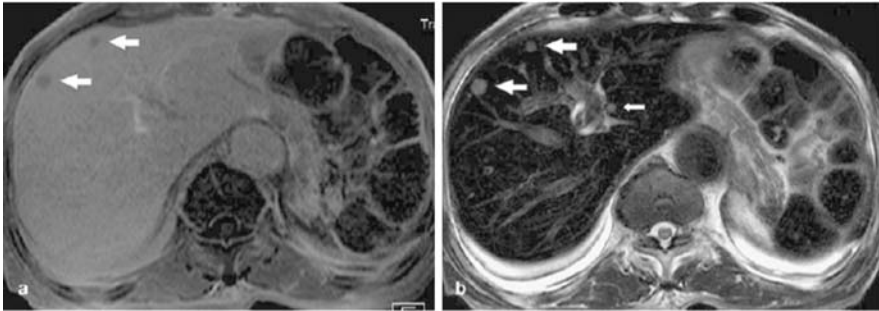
Multiple liver metastases in a 48-year-old man with gastric carcinoma: (a) gadobenate dimeglumine-enhanced 1-h delayed phase MR image shows two low signal intensity liver masses (*arrows*), (b) superparamagnetic iron oxide-enhanced respiratory-triggered T₂-weighted turbo spin echo image shows another tiny high signal intensity mass (*small arrow*) as well as two masses (*large arrows*) in the right lobe of the liver. Copyright © (2005) Springer-Verlag. All rights reserved
